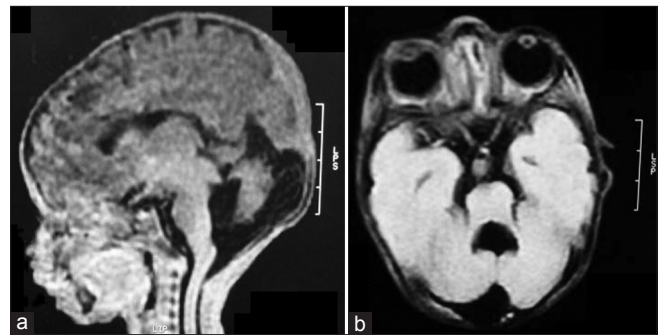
Magnetic resonance imaging of the brain showing elongated 4th ventricle with hypoplastic cerebellar vermis (on T1-W sagittal image) leading to apposition of the cerebellar hemisphere and stretched and elongated superior cerebellar peduncle giving the midbrain an appearance of “Mollar Tooth” (on T1-W axial image)
